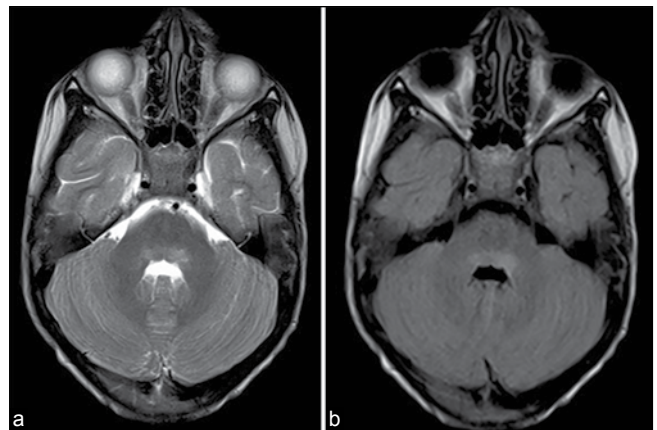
Case 2: Axial T2/FLAIR MR images show hyperintense signal involving dorsal pons
